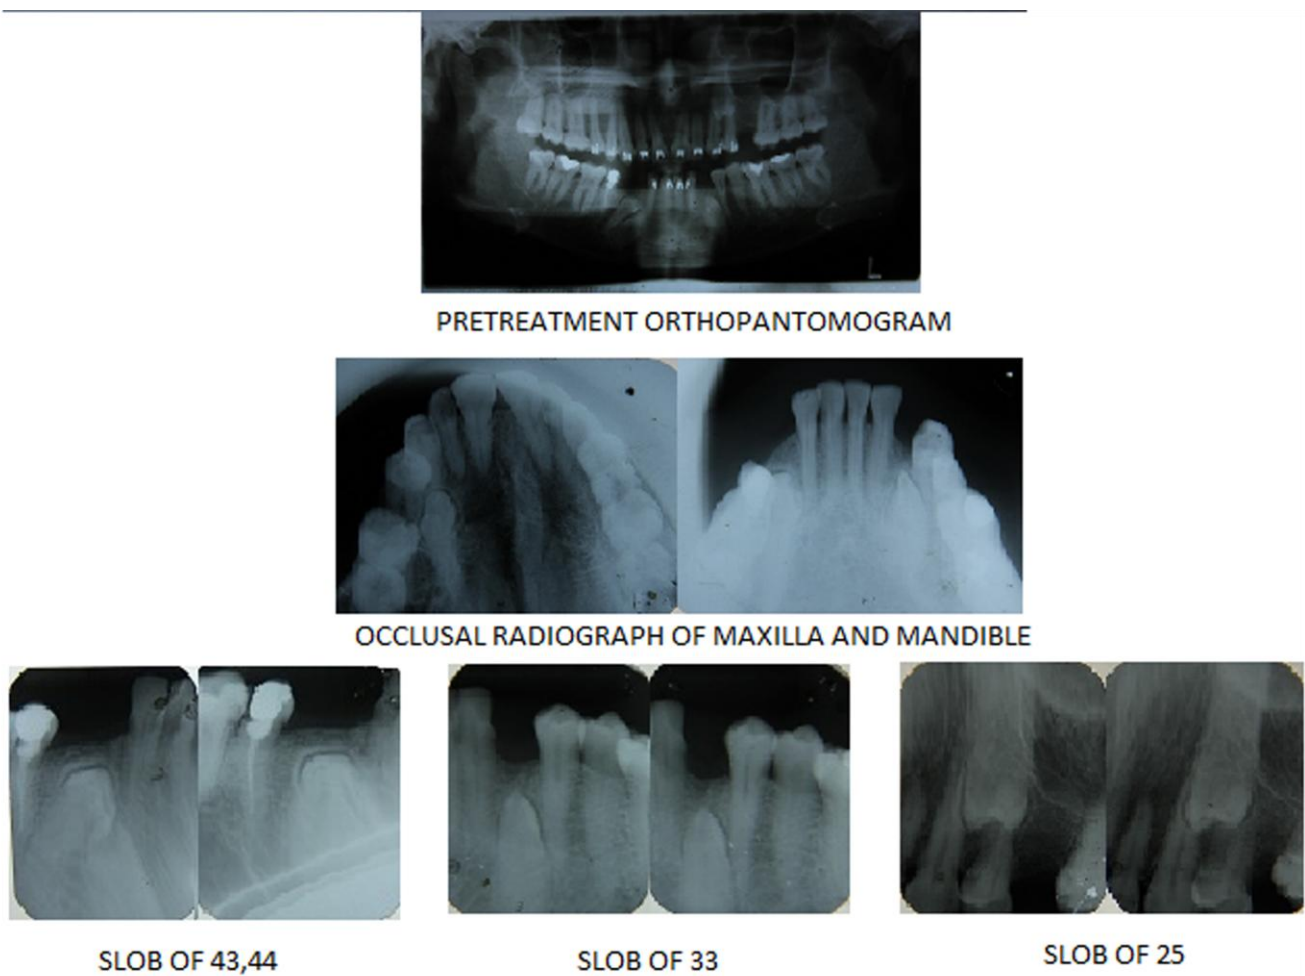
Pretreatment radiographs
